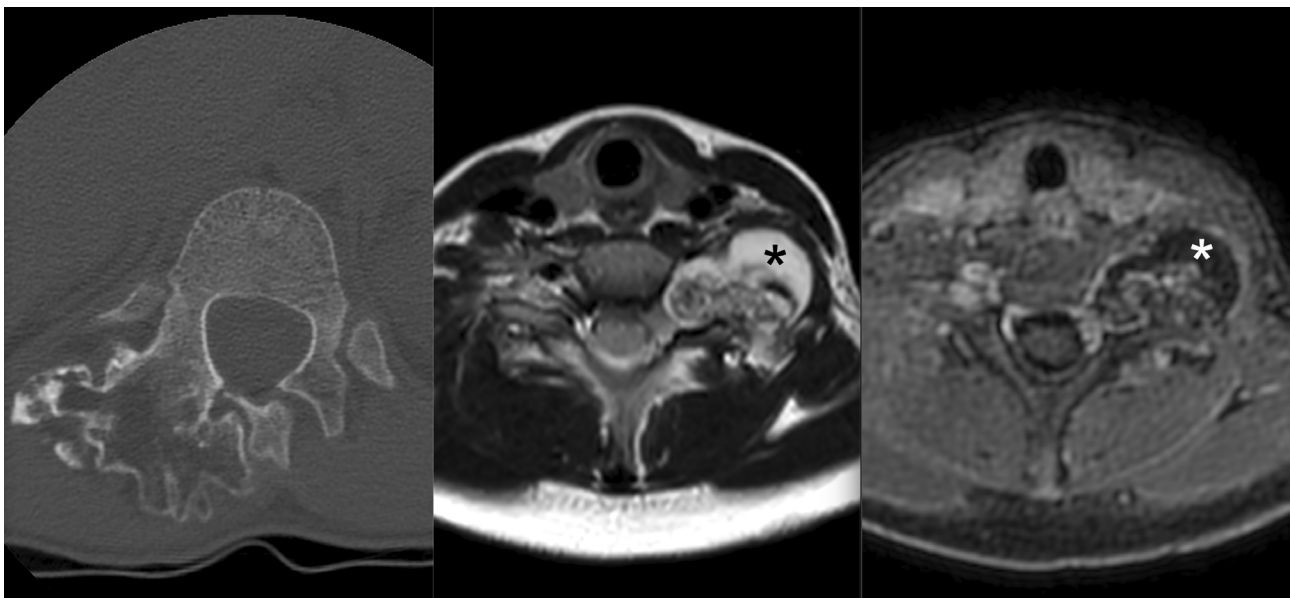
Vertebral osteochondromas in two separate patients. Although corticomedullary continuity with the host bone is usually best appreciated on CT (left image: large osteochondroma of the T12 posterior elements in a 12-year-old girl), MRI uniquely demonstrates and permits assessment of the cartilage cap (asterisks in the center image and the image on the right). Axial T2WI (center) and contrast-enhanced fat-suppressed T1WI (right), showing osteochondroma arising from the left C7 transverse process in an 11-year-old boy.
